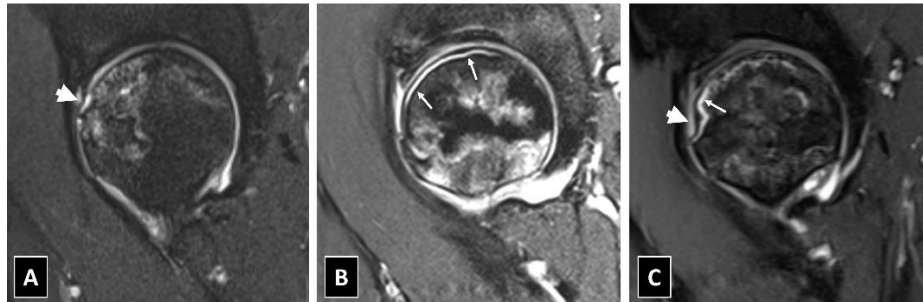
Sagittal PD Fat Sat MR images show cortical deformity (arrowhead in A and C) and subchondral dissection (arrows in B and C).
